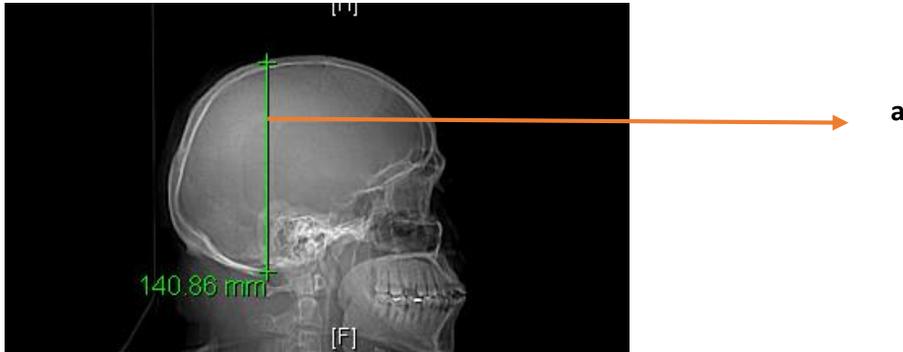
CT Brain- Scan Length from Topographic Image (Bv)
